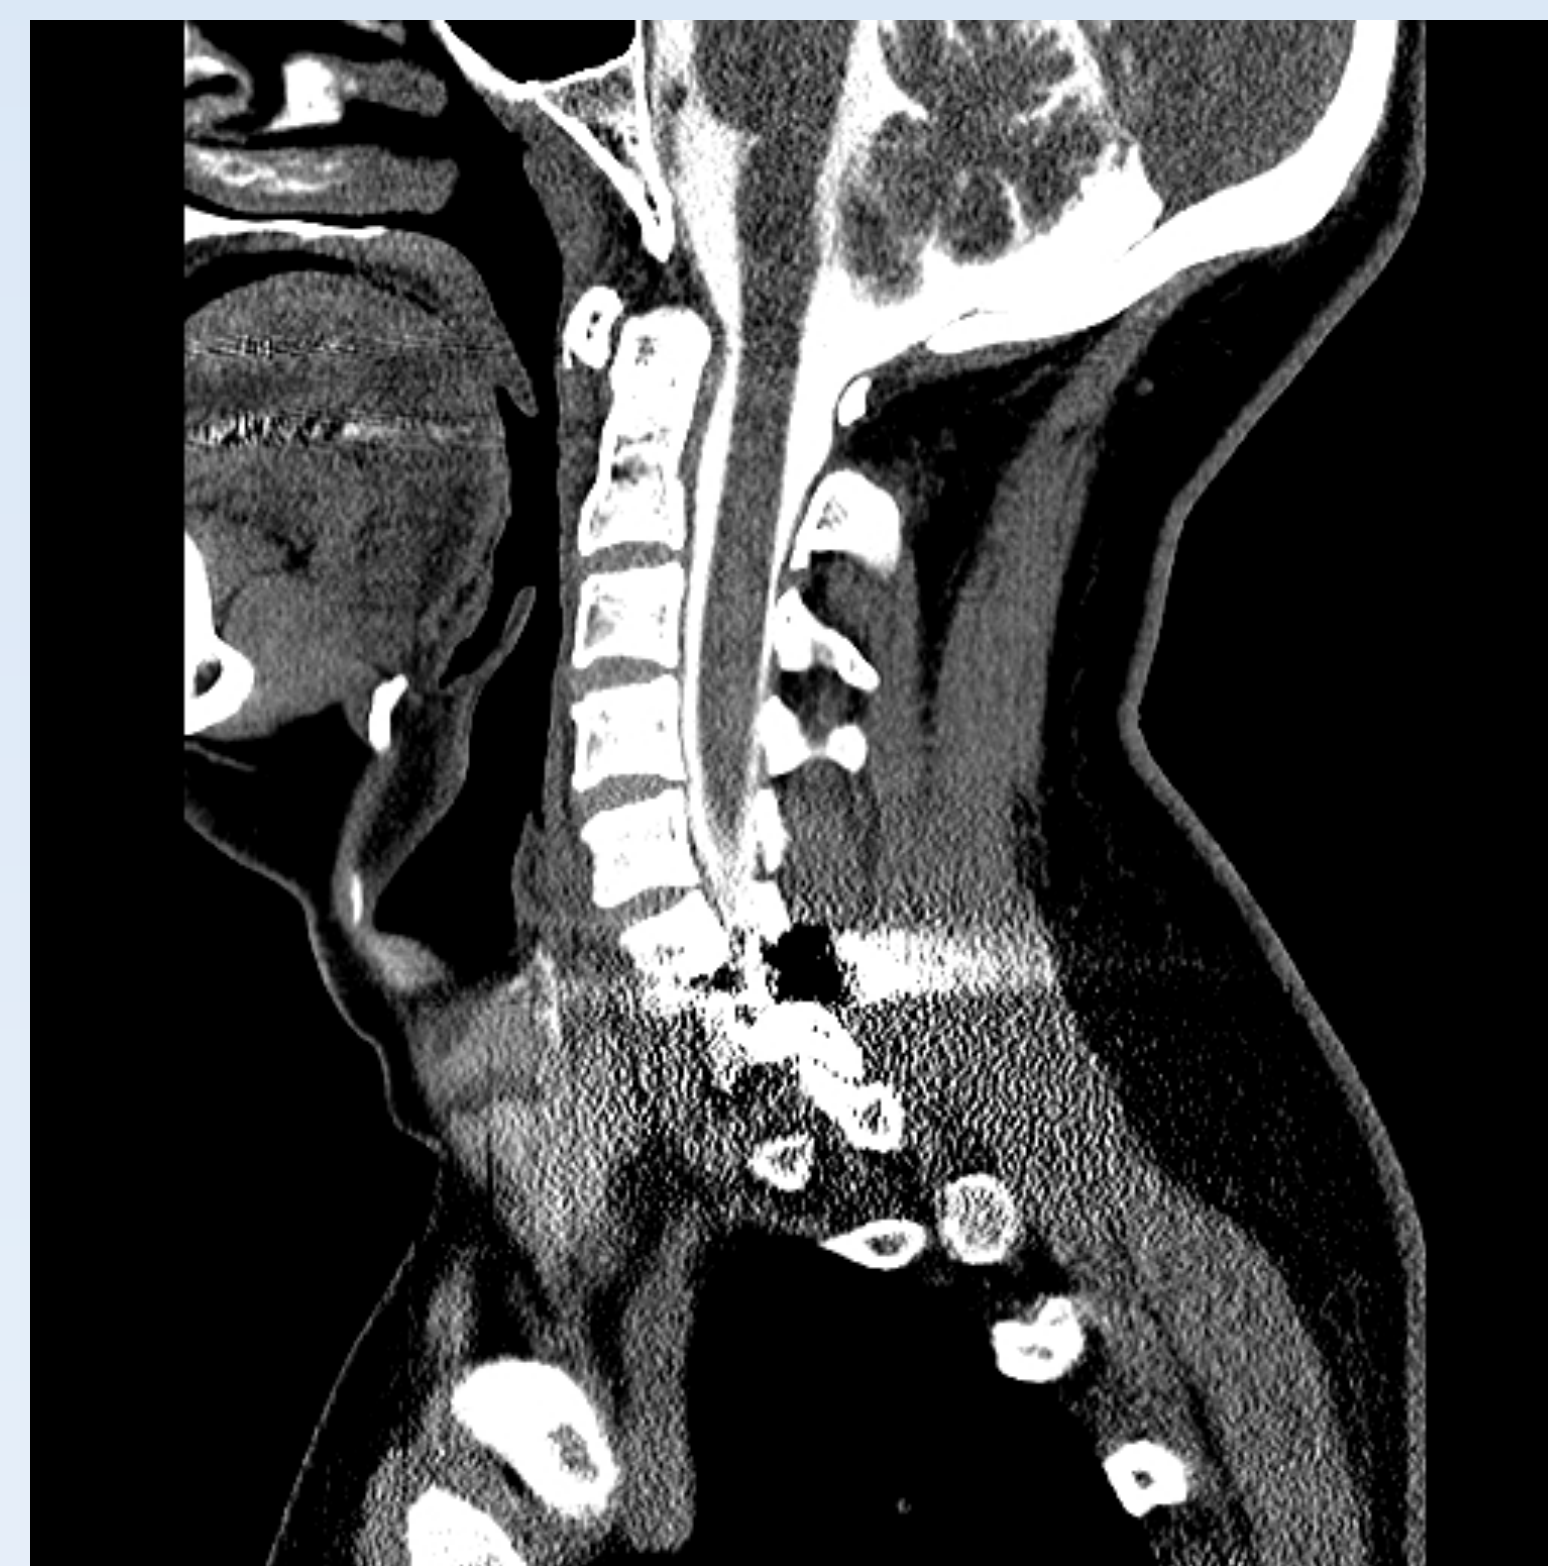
Initial CT Myelogram
